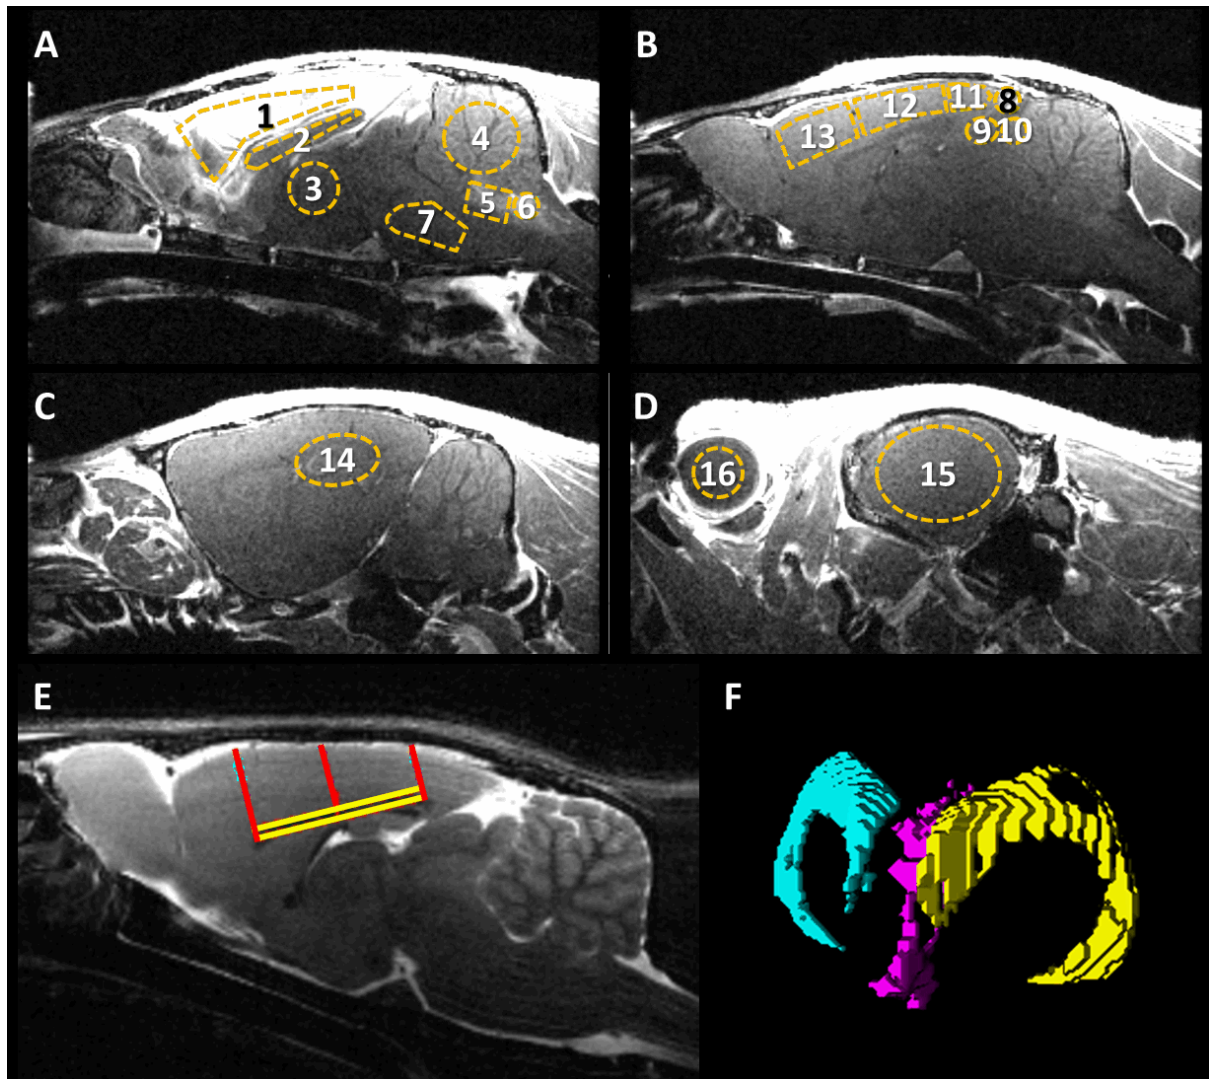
Magnetic Resonance Imaging (MRI)
